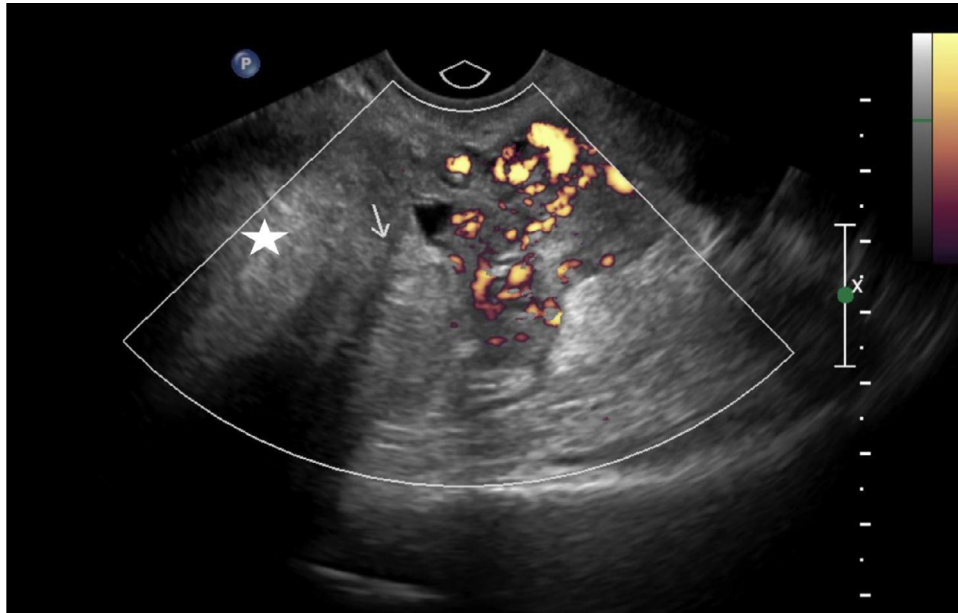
Power Doppler image of the stalk region of the pedunculated leiomyoma (arrow) demonstrates lack of blood flow, concerning for torsion. The large leiomyoma extends outside of the field of view (star).
